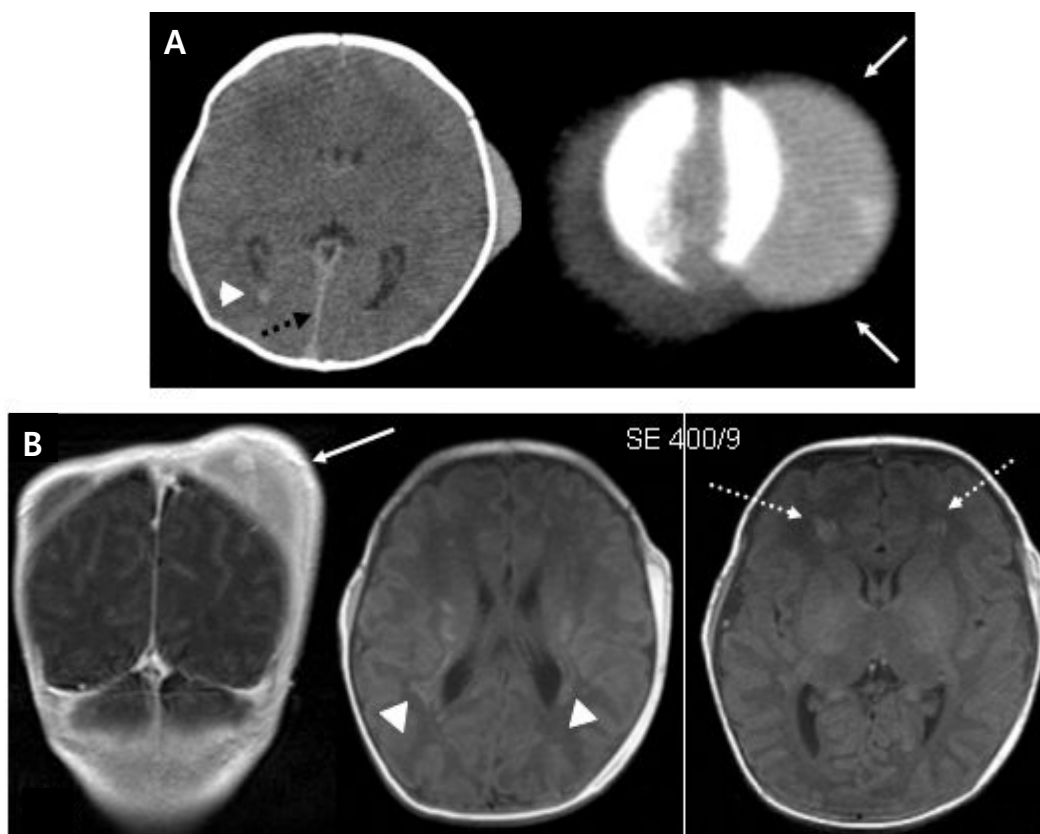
The radiologic findings showing subgaleal hematoma (SGH). (A) The brain CT scan reveals huge SGH on left parieto-occipital area (arrow) along with subdural hemorrhage at the tentorial edge (dotted arrow) and small intraventricular hemorrhage in the occipital horn of right lateral ventricle (arrowhead). (B) Brain MRI at the age of 7 days shows huge subgaleal hematoma on left parieto-occipital area (arrow), hemorrhage at the bilateral frontal area (dotted arrow) and periventricular white matter (arrowhead).
